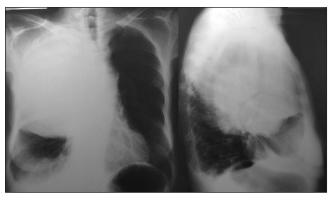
Chest x-ray showing homogeneous parenchymal consolidation due to the presence of a voluminous inflammatory exudate that produces the bulging of an interlobar fissure. This radiographic presentation was considered to be typical of *Klebsiella* infection
